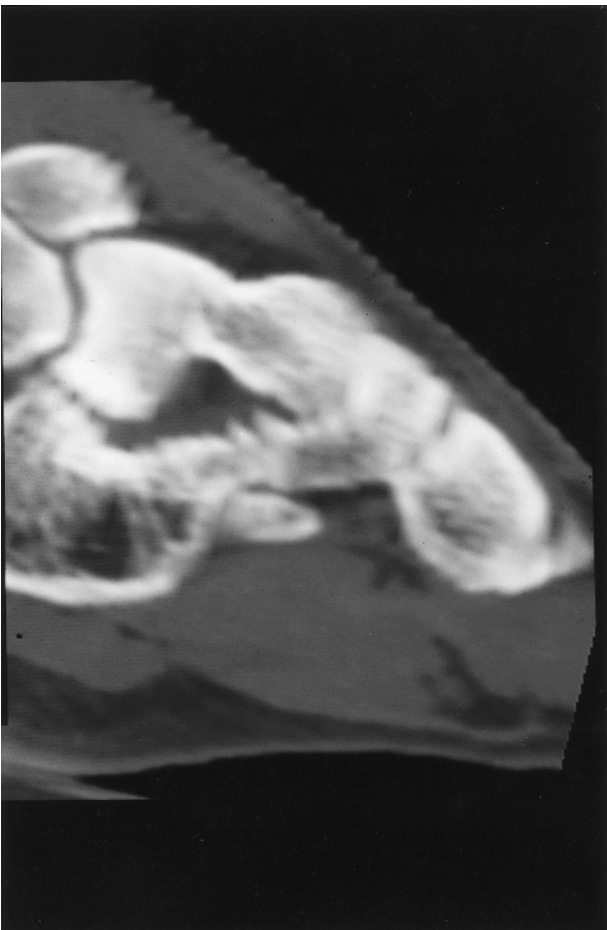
Talonavicular coalition is best demonstrated on sagittal CT scan reconstruction in a patient with recurrent ankle sprains.
